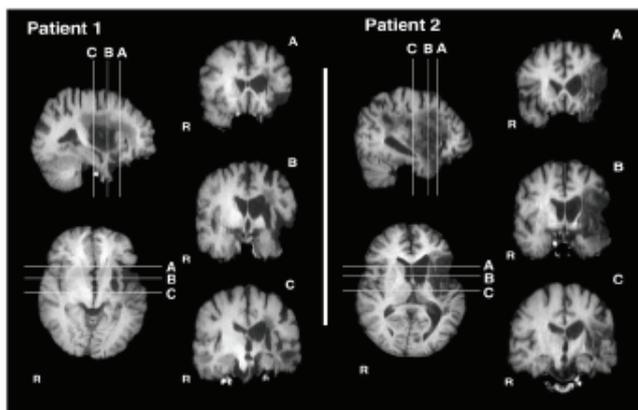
MR imaging pictures showing the extent of the lesions. Both patients had the severe left middle cerebral artery (MCA) strokes within the insular cortex. Patient 1's lesions involved large portions of the insula, parts of second somatosensory cortex (SII), basal ganglia, and white matter. Patient 2's lesions were more extensive than patient 1's and involved large portions of the insula and SII, parts of basal ganglia and white matter. Patient 2 also suffered from hemorrhagic transformation of the ischemic stroke. (Starr et al., 2009)
